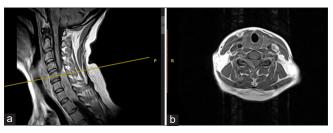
T1 Gadolinium-enhanced magnetic resonance imaging of the cervical spinal cord. (a) Sagittal view showing an extradural mass at the C5-C7 levels with severe cord compression. (b) Axial view demonstrating foraminal and extraforaminal tumor extension along the right nerve roots.
